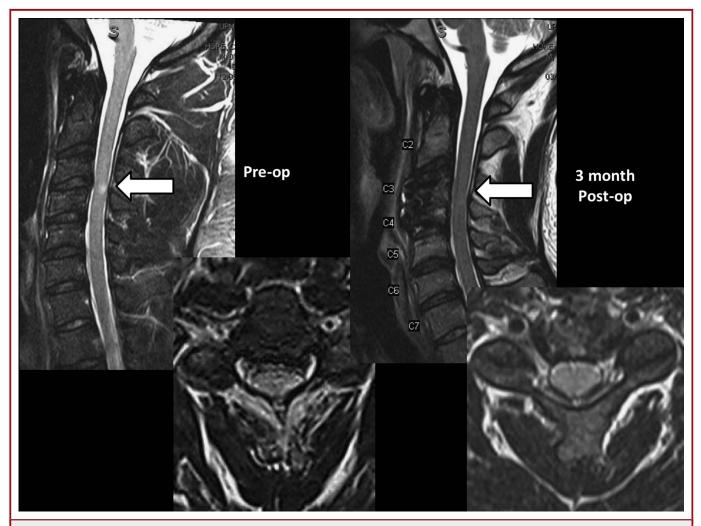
Patient 10 showing both sagittal and axial magnetic resonance images of the C5-6 level preoperatively and 3 months and 3 years postoperatively. The arrows point to the persistent hyperintensity cord changes at the injury site.
